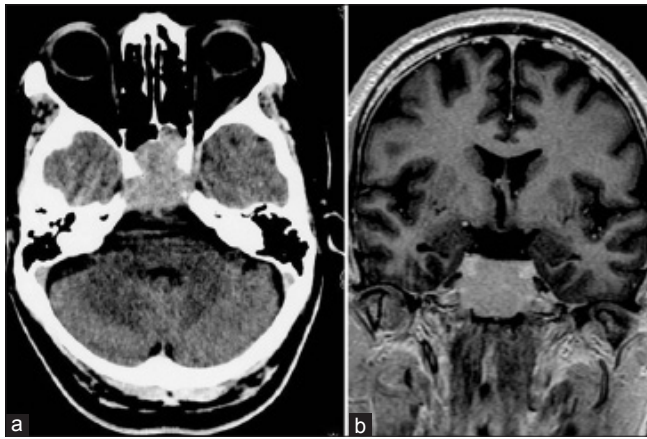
(a) Magnetic resonance imaging brain shows an expansile lesion involving entire clivus and eroding the posterior wall of sphenoid sinus. (b) Saggital view of the lesion
